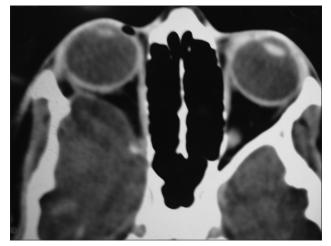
CT axial showing right temporal lobe protruding toward the right orbit
